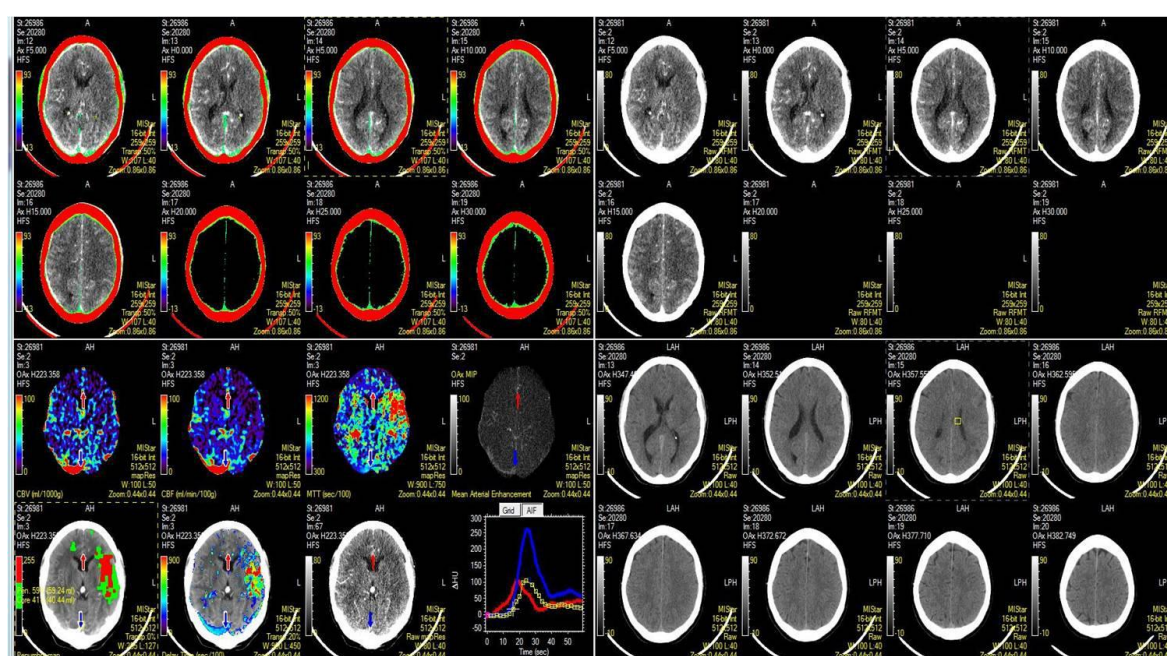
CTP, CT Coregistration- step 3
